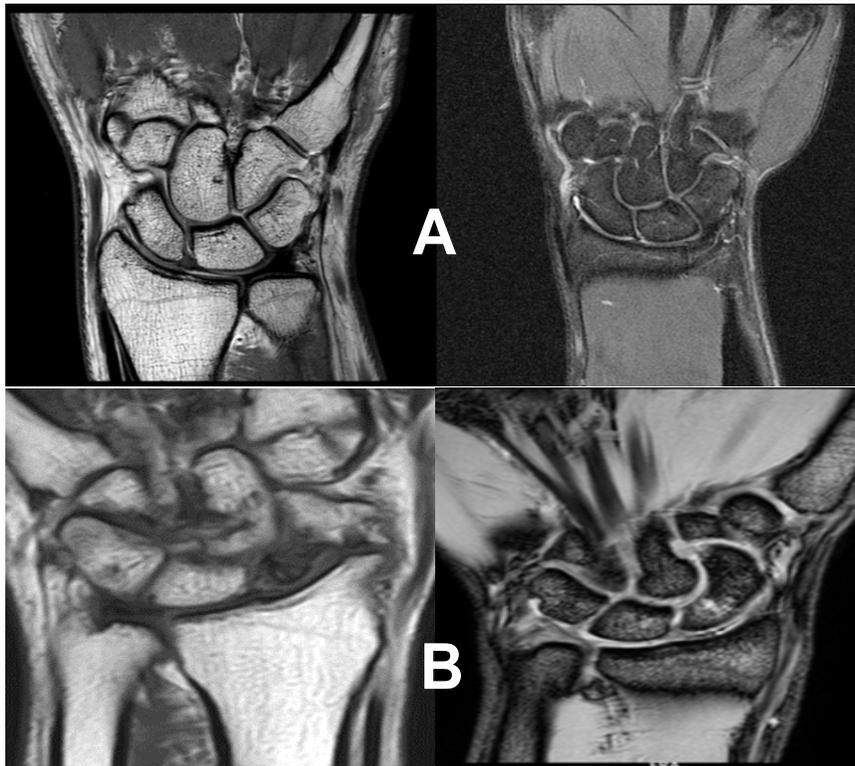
A) Normal MRI of wrist followed by B) decreased T1 weighted and T2 weighted MRI signals (diffuse) more in favour of late necrotic phase
